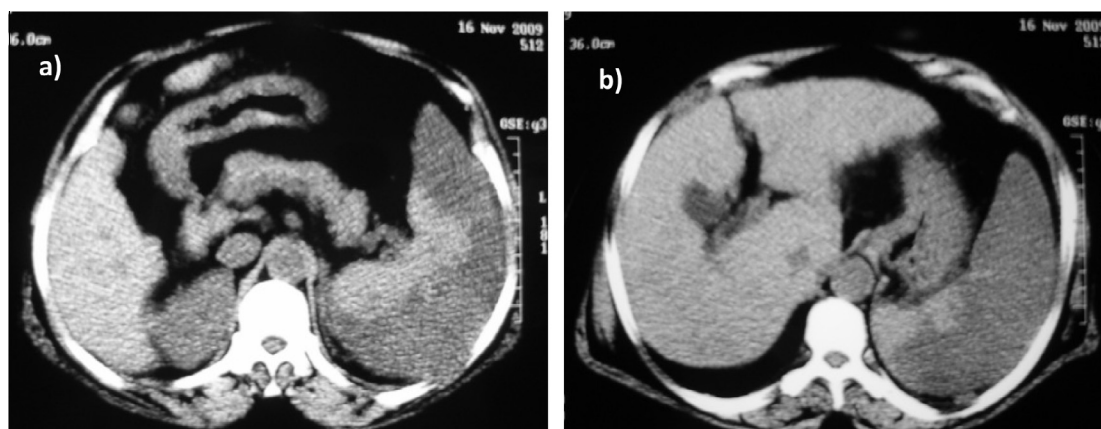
(a) and (b) Unenhanced CT scan 1 week after the 2nd session showing extensive splenic infarction counting for about 80%.
